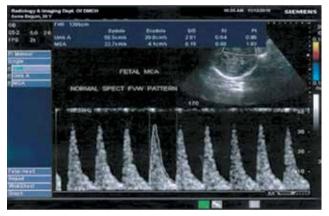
Color Doppler of the normal middle cerebral artery showing a normal MCA waveform pattern with high resistance, low diastolic flow and increased pulsatility index
